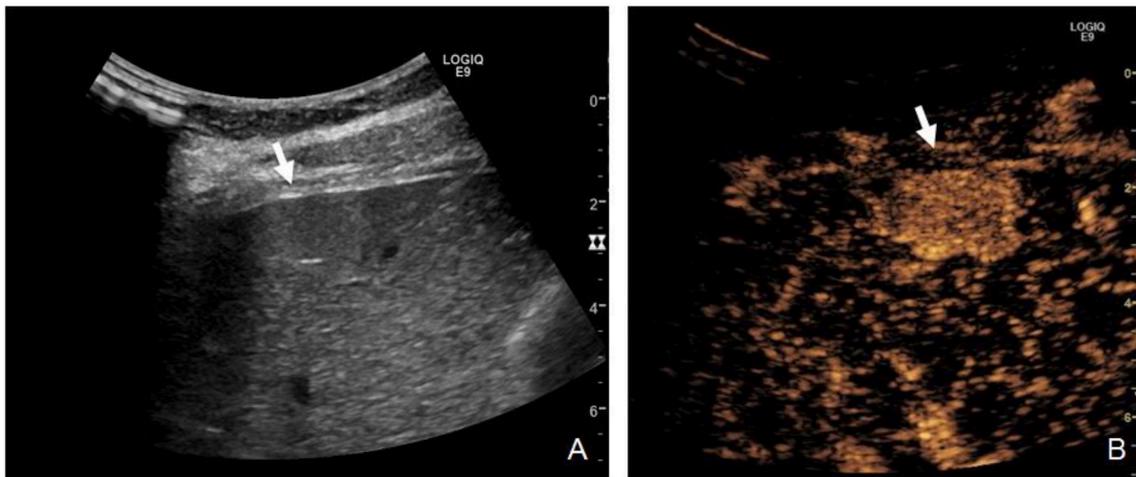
Contrast enhanced ultrasound (CEUS) of the main focal hepatic lesion.
